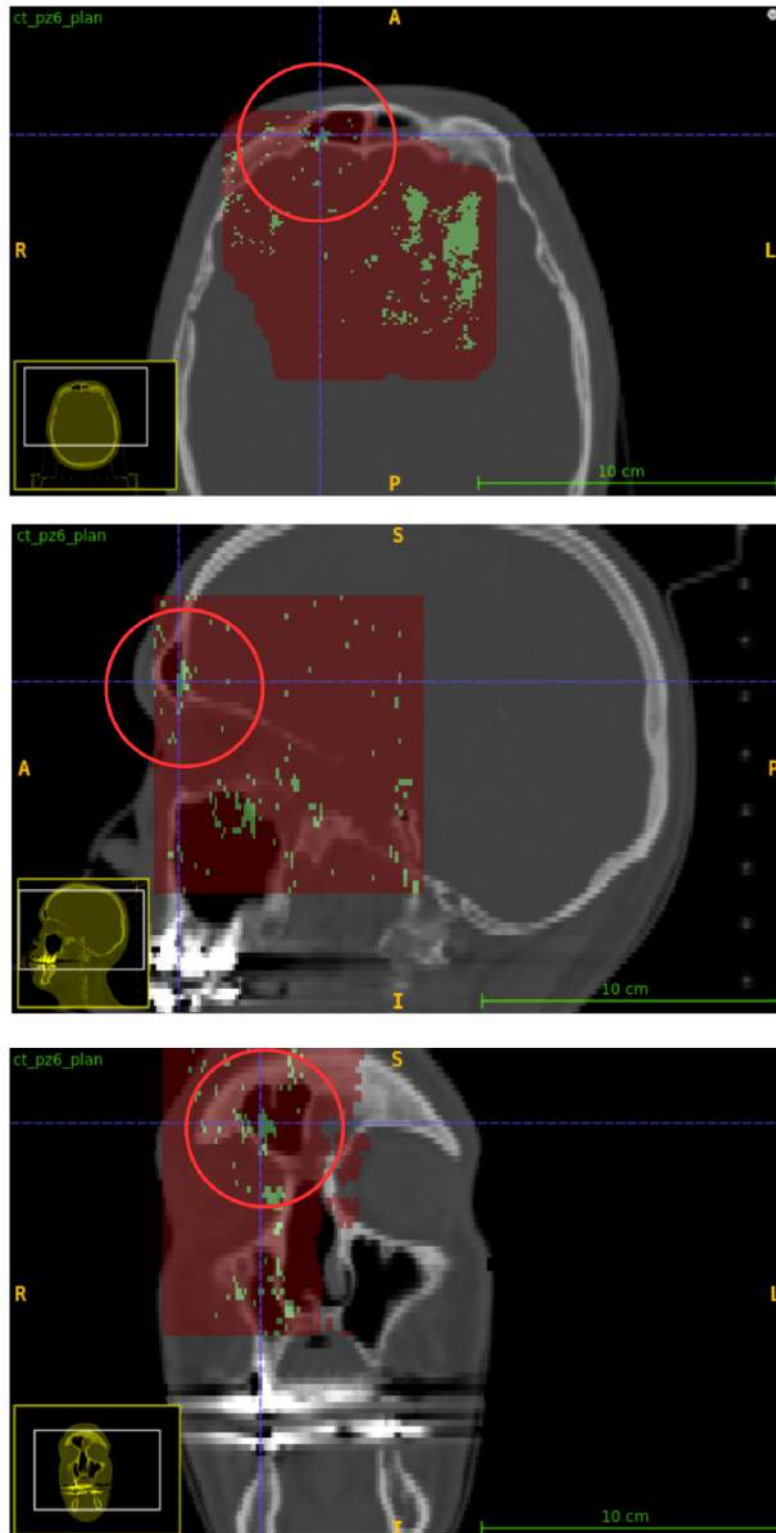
Pass rate map for  $DD = 0.25\%$ ,  $DTA = 20$  mm,  $DTH = 0\%$ , showing the superficial morphological variation (red circle) in axial, sagittal and coronal views (from top to bottom), overlaid on the planning CT.
